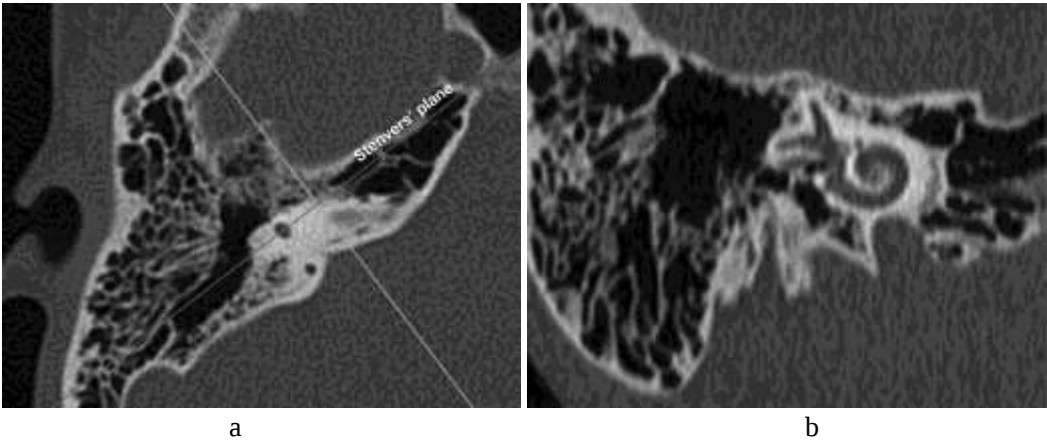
a) Axial CT passing through the superior semicircular canal (SSCC) with superimposed DICOM references lines for a MultiPlanar Reconstruction (MPR) among Stenvers' plane obtained by tilting the MPR plane perpendicular to the SSCC; b) the cochlea is exposed from basal turn to apex on the resulting MPR plane.
